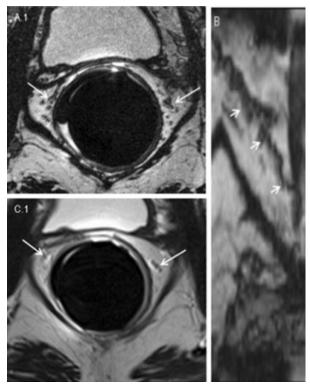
A 61-year-old man after radical retropubic prostatectomy (preoperative International Index of Erectile Function Five-Item [IIEF-5]: 21 points; postoperative IIEF-5 at 6 months: 5 points; postoperative IIEF-5 at 12 months: 6 points). A.1 and C.1 = axial sections at 6 months (A.1) and 12 months (C.1) after surgery obtained by 3D T2-weighted isotropic image at the level of prostatic fossa. The arrows indicate neurovascular bundles' (NVBs) location. Radiologists assessed bilateral high signal intensity on left and right NVBs. B = right side; coronal multiplanar reconstructions obtained by axial 3D sequence (12-month evaluation). Note that NVB on B image seems to be bulging and with an irregular course, according to interfiber fluid (edema). After evaluating this image, the radiologists assessed this patient as class III under the MRI classification score.
